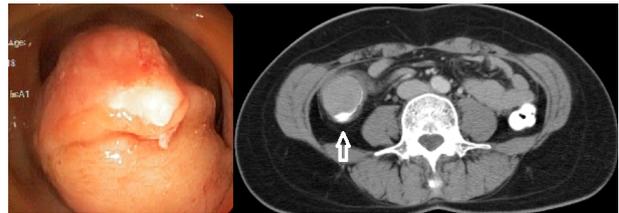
Colonoscopy revealed a large protruding lesion in the right colon (Figure 1, left). Abdominal computed tomography demonstrated a solid mass (Figure 1, right arrow).
